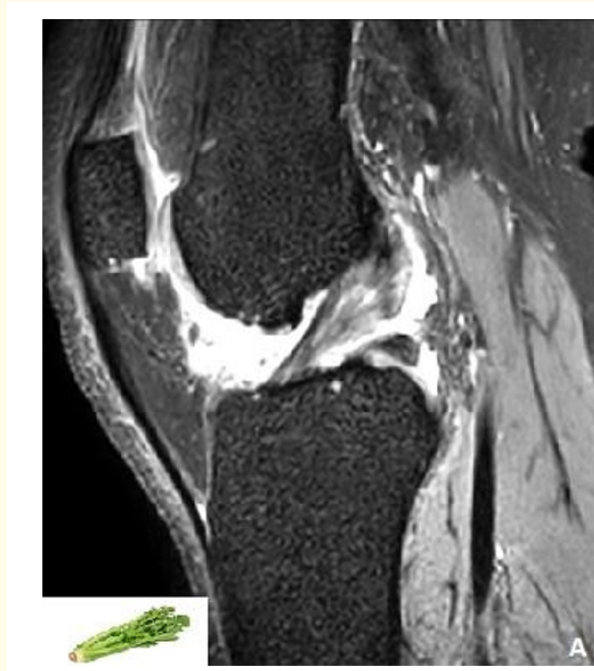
MRI of the knee in sagittal DP section T2 showing mucoïd degeneration of the anterior cruciate ligament with a Celery stem appearance.
